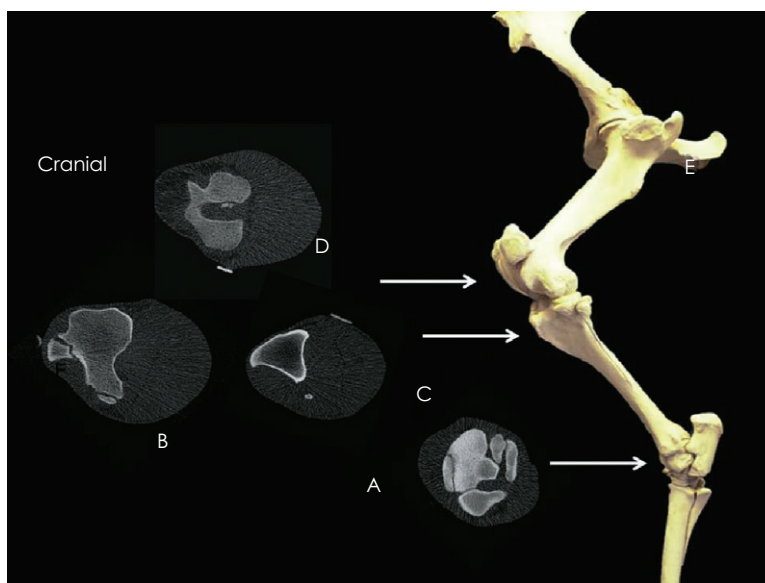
Cases where CT was used in proximal anatomical regions of the pelvic limb. (A) fracture of the central tarsal bone; (B) fracture of the tibial crest; (C) bone fragment near proximal tibia; (D) bone fragment in the intercondylar space of distal femur.
